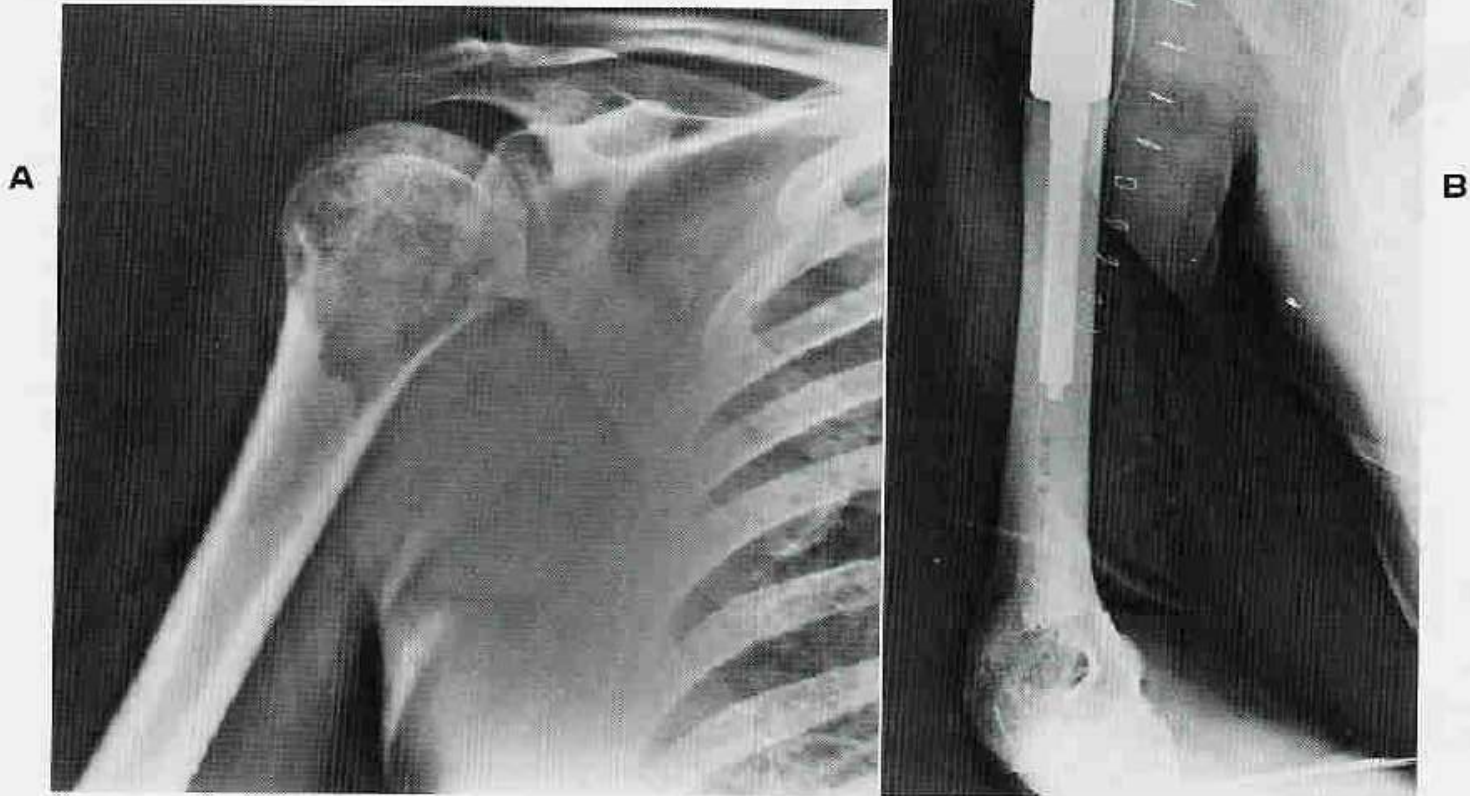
A, Plain radiograph showing an extensive lytic lesion in the proximal humerus. B, Prophylactic internal fixation was performed to prevent pathologic fracture. The patient, who experienced pain primarily in the hip, would have been put on crutches to reduce stress on the involved femur. A bone scan and x-ray films obtained to exclude other sites of metastatic involvement identified this lesion in the humerus. The humerus would certainly have fractured if all of the patient's weight had been displaced to the upper extremities with crutches.
